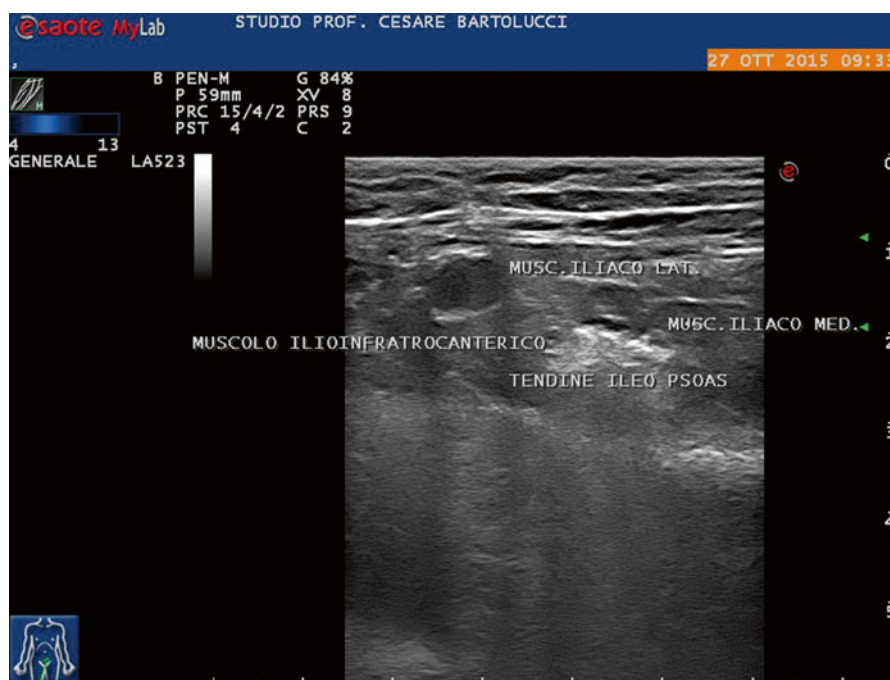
Sonographic view of iliopsoas tendon in contact with the acetabular rim
